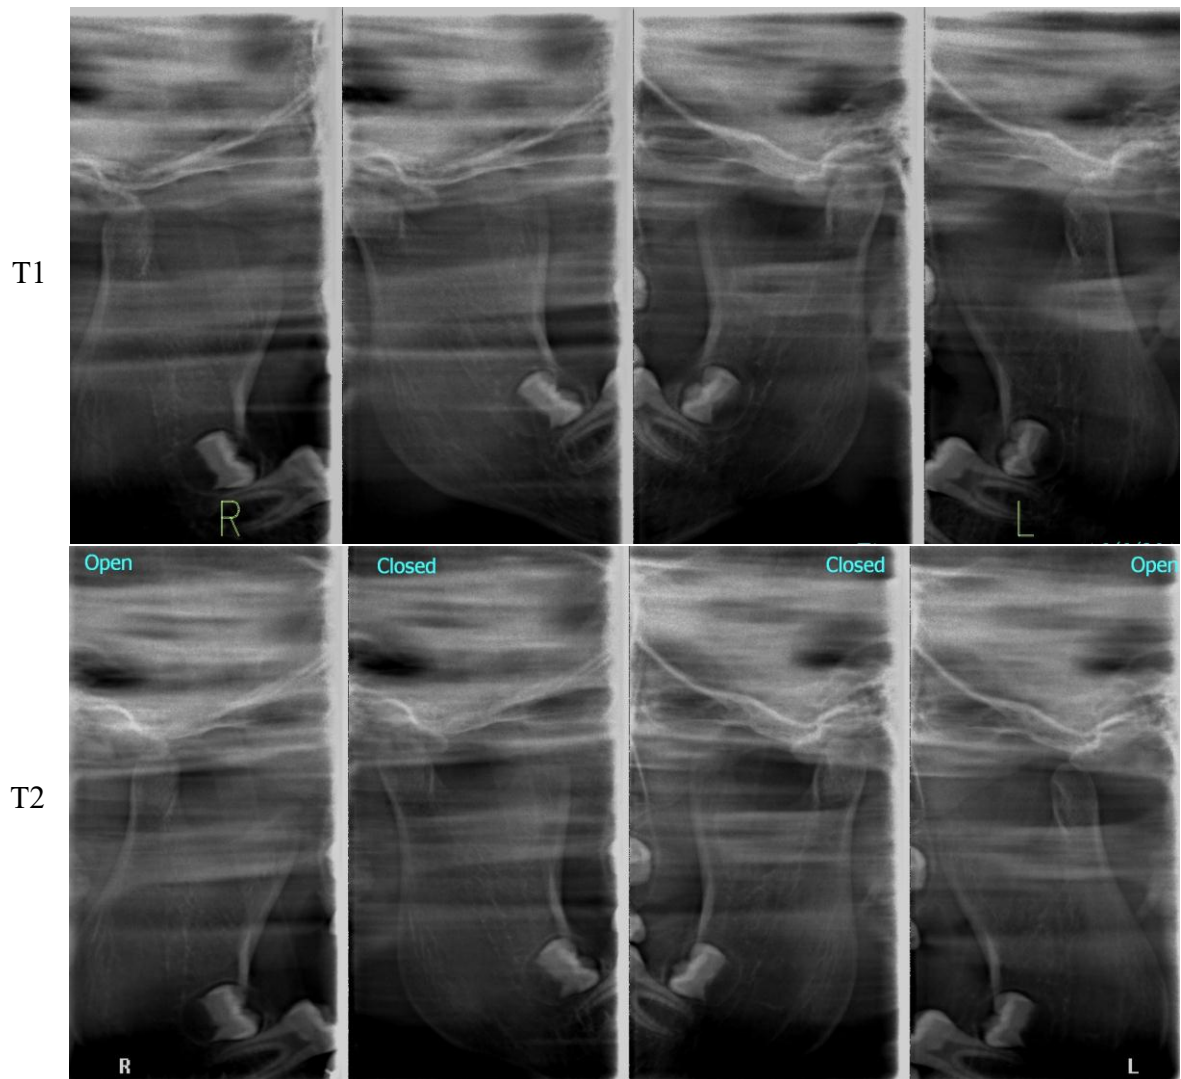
Adolescent girl aged 11 years 11 months before EZJA treatment. CT of left and right TMJ from different treatment stages was shown: at start of treatment (T1), at 9 months of treatment, 2 months after final position of EZJA (T2)
